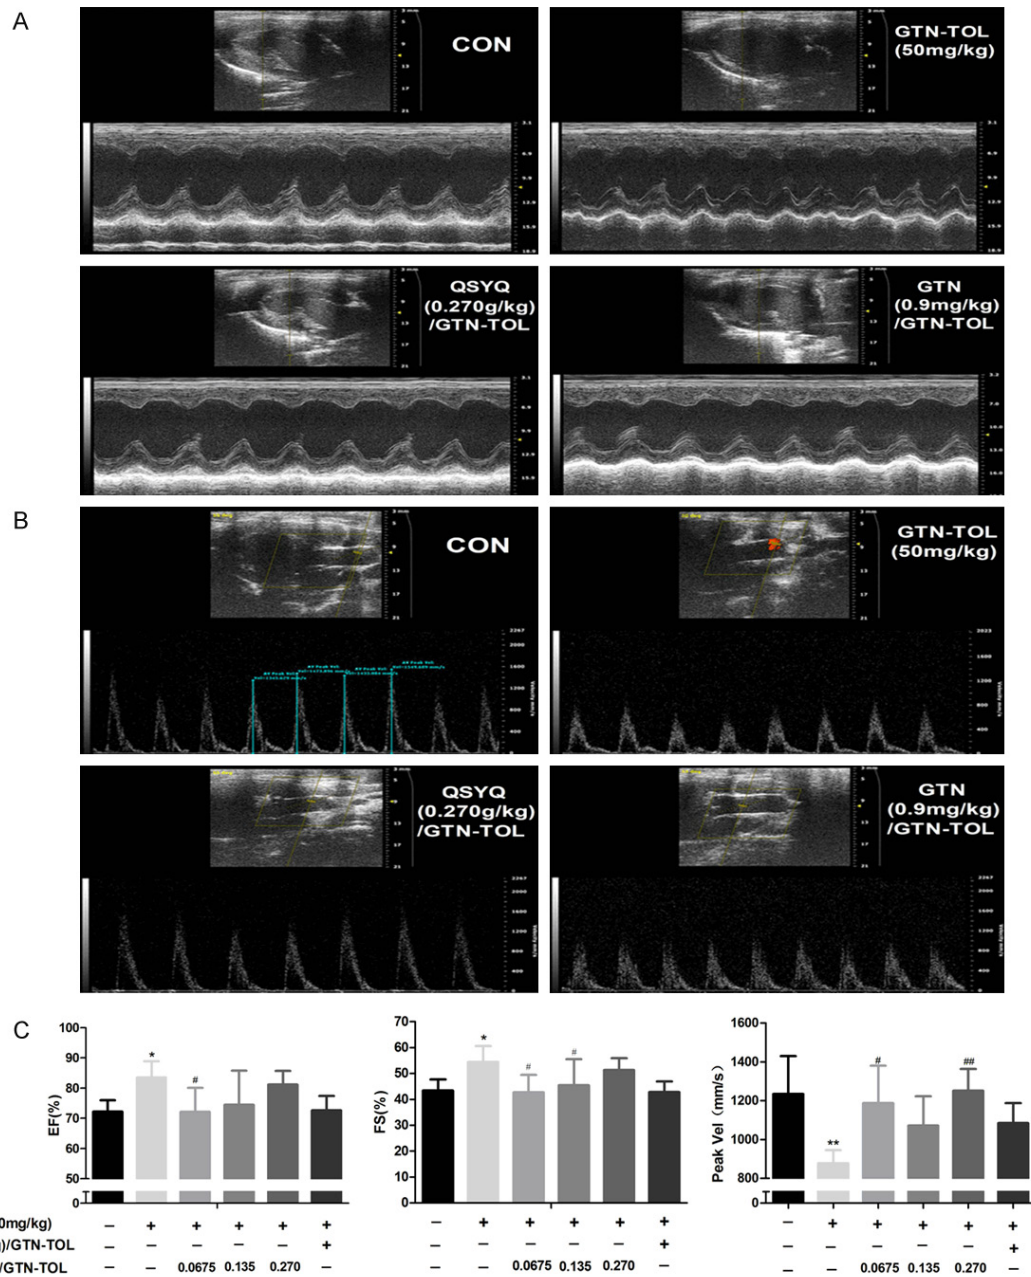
Echocardiography evaluation. GTN and QSYQ combination treatment protected the cardiac function in vivo. A. Representative M-mode echocardiograms of control and GTN-TOL treated and combination-treated groups showed the wall motion. B. Peak Vel echocardiograms on Doppler of the left ventricular outflow tract. C. Ejection fraction (EF), fractional shortening (FS) and peak Vel of LVOT in the groups.
